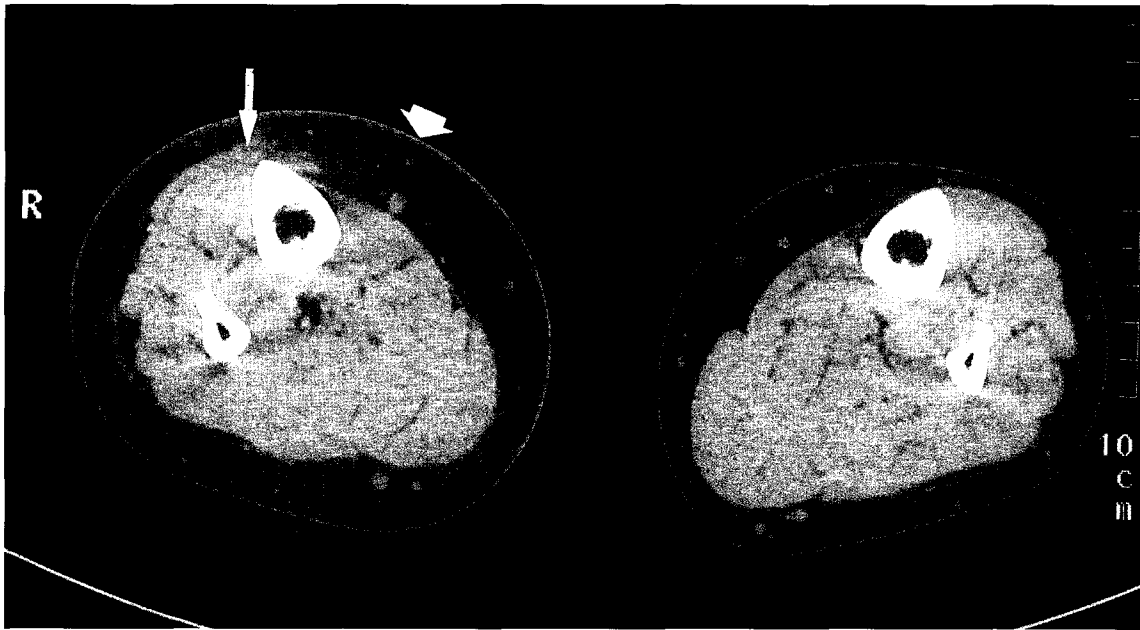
Unenhanced CT scan of unilateral lymphedema of the right lower limb. Skin thickening (large solid arrow) with subcutaneous fat infiltration (trabeculae underlying parallel to the dermis and perimuscular collection in a non-dependent location) (small solid arrow).
